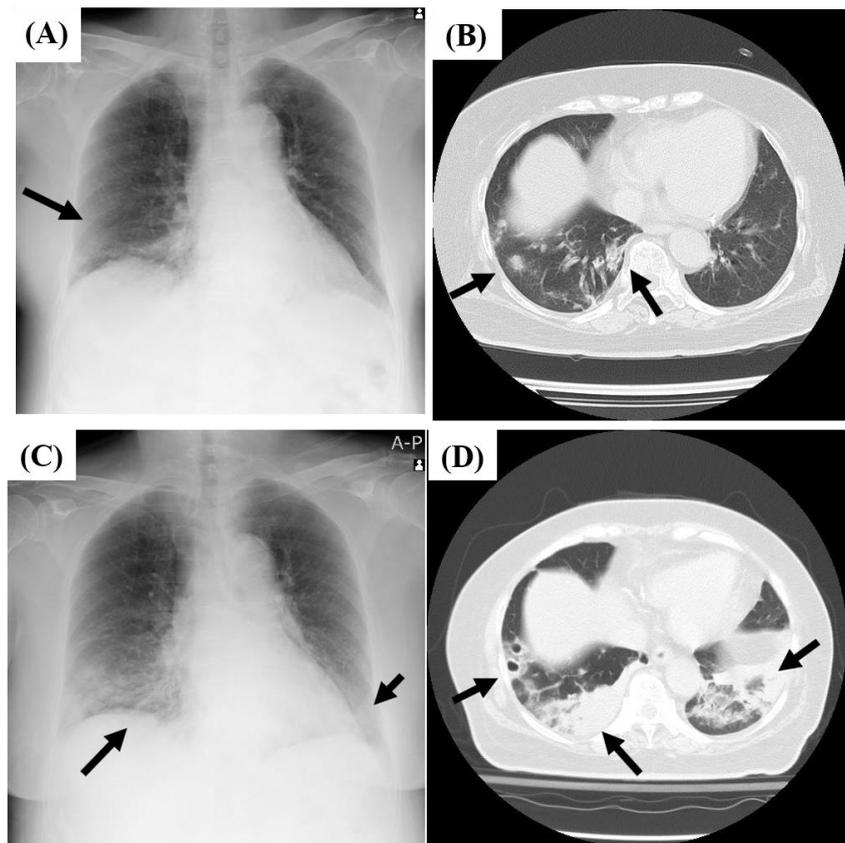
Chest X-ray (A) and CT (B) of the case 1 patient on admission. Infiltration shadows and nodules are seen on chest X-ray and computed tomography (CT) on day 0 in her right lung field (Figure 1A,B), but these lesions are widespread, and there are multiple nodules with cavity formation on day 3 (Figure 1C,D).
